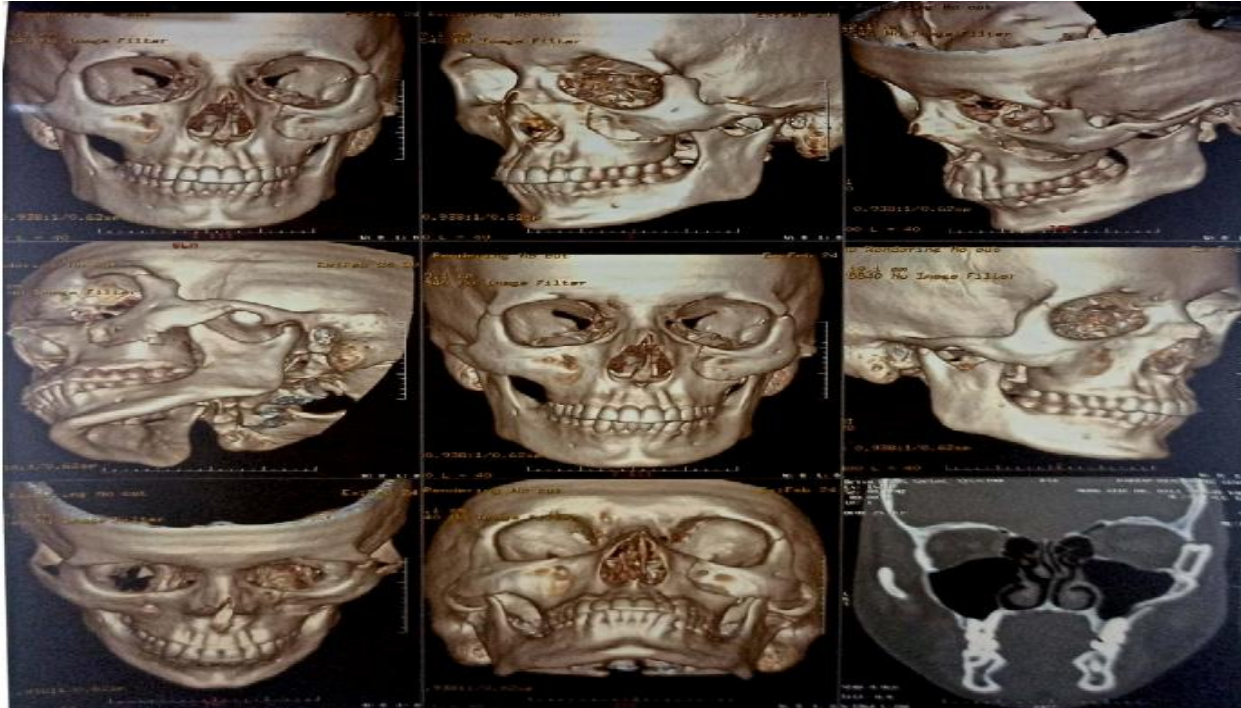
Cone beam CT views showing the fractures in the mandibular region
